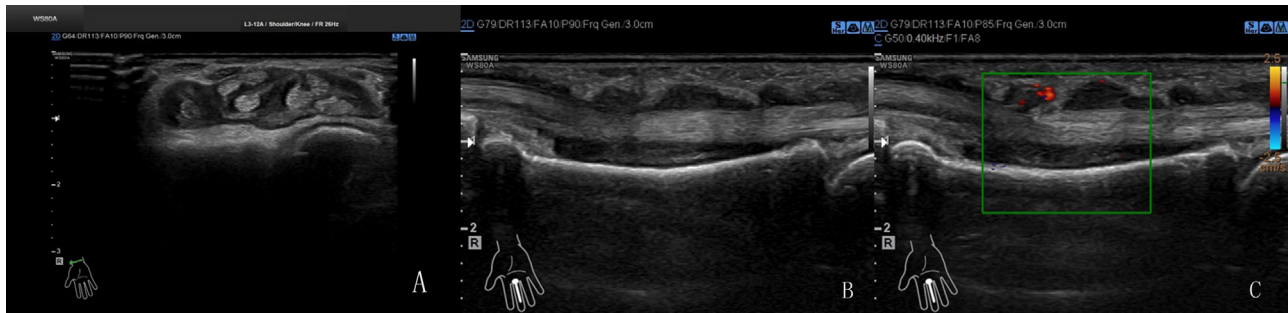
Ultrasonic images of the wrist and hand: (A) Axial grey-scale image at the level of wrist joint demonstrates thickened and decreased echogenicity surrounding the tendons in the carpal tunnel and the median nerve had a deformity as a result of compression. (B) Longitudinal US images showing the synovitis and tenosynovitis of the distal phalanx of the middle finger with peripheral and internal flow on (C) color Doppler assessment.
